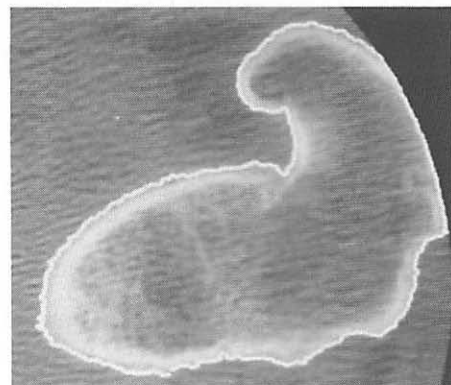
Segmentation of a CT image of a femour
